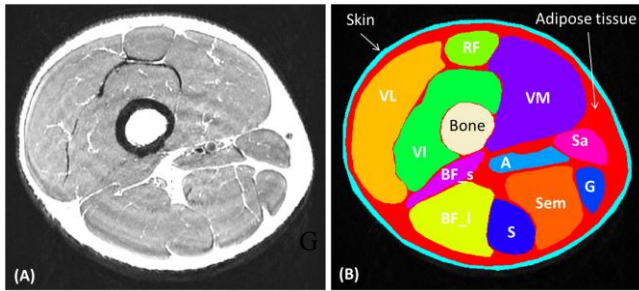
MRI anatomical (A) and segmented (B) images including 14 regions of the thigh: femoral bone, skin, adipose tissue, and 11 muscles (Rectus Femoris (RF), Vastus Lateralis (VL), Vastus Medialis (VM), Vastus Intermedius (VI), Biceps Femoris (Short Head) (BF_s), Biceps Femoris (Long Head) (BF_l), Semitendinosus (S), Semimembranosus (Sem), Adductor (A), Sartorius (Sa), Gracilis (G)).
